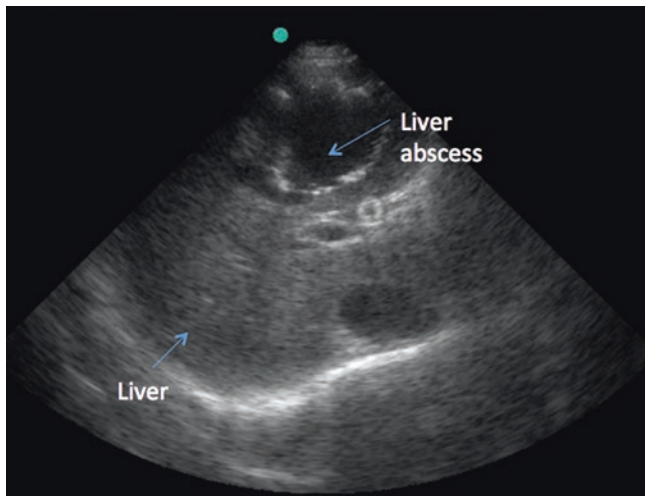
Bedside ultrasound for liver disease. A point-of-care ultrasound shows a hypoechoic (black) lesion in the liver surrounded by a hyperechoic rim in a patient admitted with abdominal pain, right upper quadrant tenderness, malaise, and fever. The percutaneous drainage subsequently revealed polymicrobial pyogenic liver abscess. See also Video 37.16
